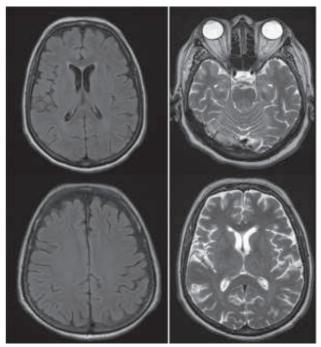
T2 and FLAIR sequences of MRI brain showing normal brain image.
